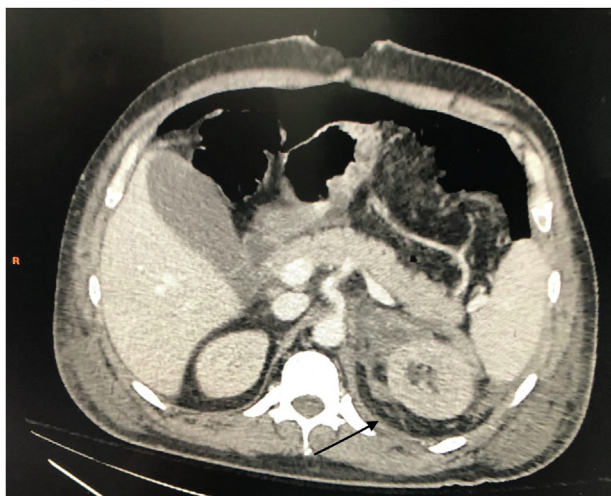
Post-operative CT. Black arrow shows retroperitoneal haematoma with perinephric fatty stranding. Adrenal haematoma has been removed.
